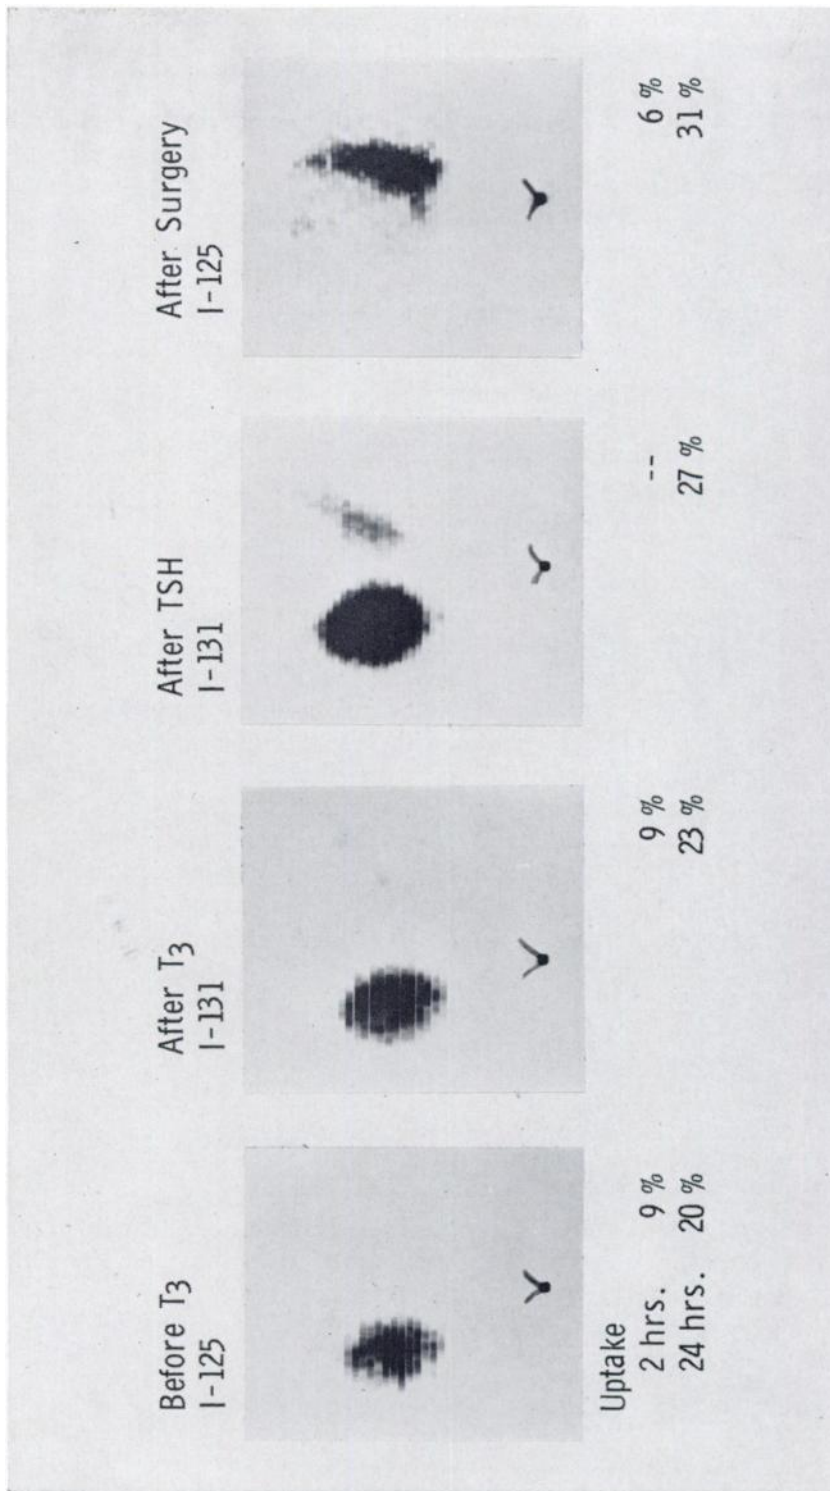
(Case 8) Thyroid scintigrams show a typical solitary hyperfunctioning nodule in the right lobe. A. Initially, all the visible iodine is in the nodule. B. Following triiodothyronine, 25 ug every 8 hours for 3 days, the scan is unchanged. C. Following 10 units of TSH, the previously suppressed left lobe is visualized. Ratio of external (corrected) counts over nodule is 2.1, left lobe 13.1. Ratio of administered doses is 2.5. This indicates TSH stimulation of the extranodular portion of the gland but not of the nodule. D. Following surgical removal of the nodule, the left lobe has resumed normal function.
